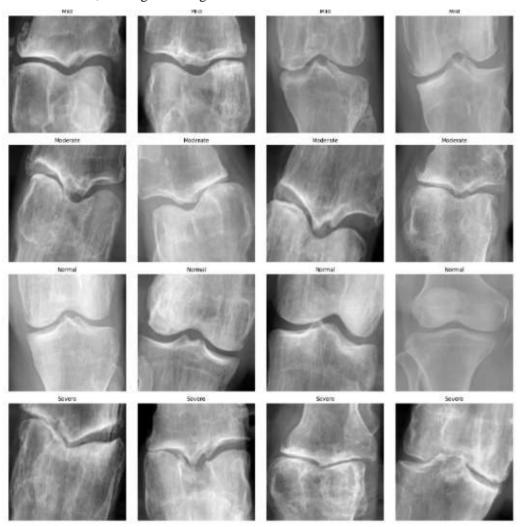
Examples of X-ray images by KL grade included in the dataset
